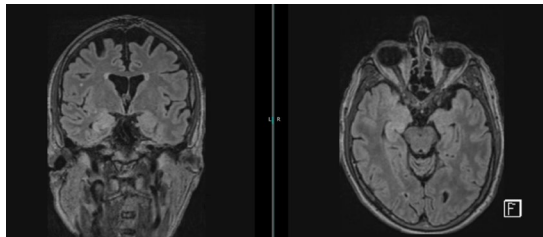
Coronal (left) and axial (right) T2 FLAIR magnetic resonance imaging demonstrating bilateral, right greater than left, anteromedial temporal T2 hyperintensities.
